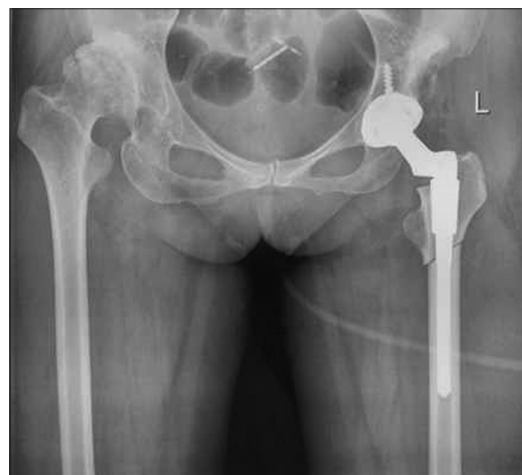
Immediate postoperative x-ray pelvis with proximal thigh and hip joint anteroposterior view showing subtrochanteric oblique osteotomy and total hip arthroplasty with S-ROM stem (case 17)
